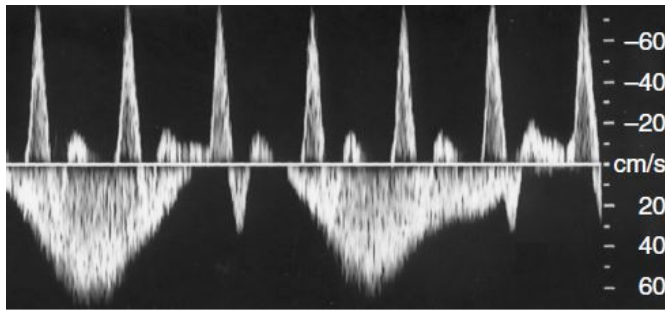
Spectral Doppler display showing arterial flow towards the transducer displayed above the baseline, and venous flow away from the transducer displayed below the baseline. Adapted from [10].
